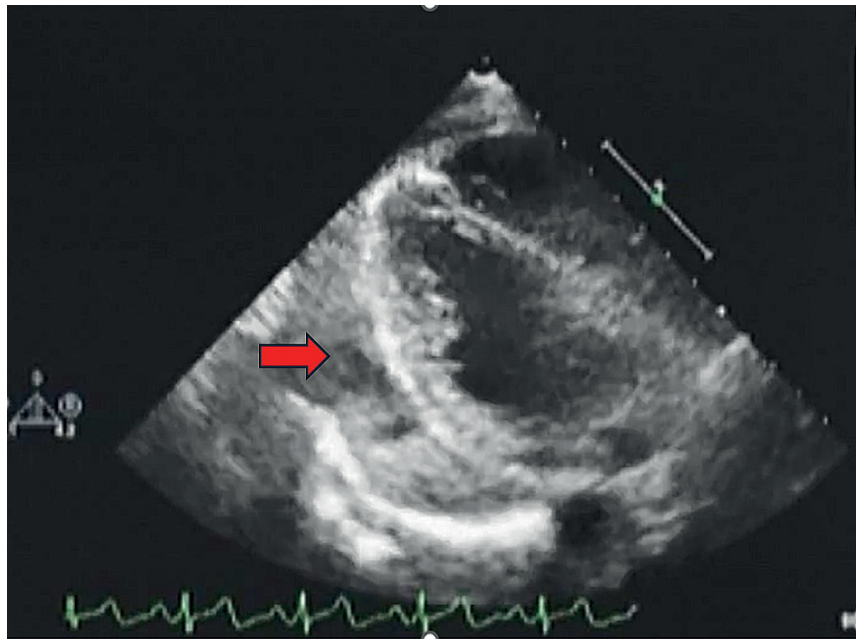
Transthoracic echocardiography with infusion of agitated saline into the pericardial space to confirm correct needle positioning during puncture.
